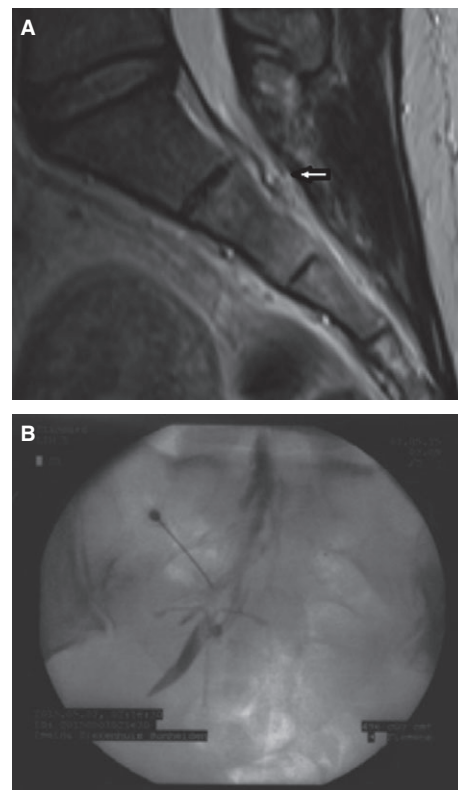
Case 2. (A) T2-weighted sagittal MRI at sacral level demonstrating a small perineural cyst at the level of the S2 vertebra (white arrow). (B) Radioscopic image of nerve root block procedure with contrast medium via the left neuroforamen S1S2 (patient in prone position), demonstrating the S2 root nerve sheath wherein the contours of the cyst are visible (at the tip of the needle). Superposition of an intrauterine device in situ.
